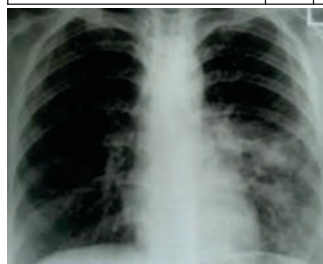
Chest x-ray showing lower lung field PTB on the left side
